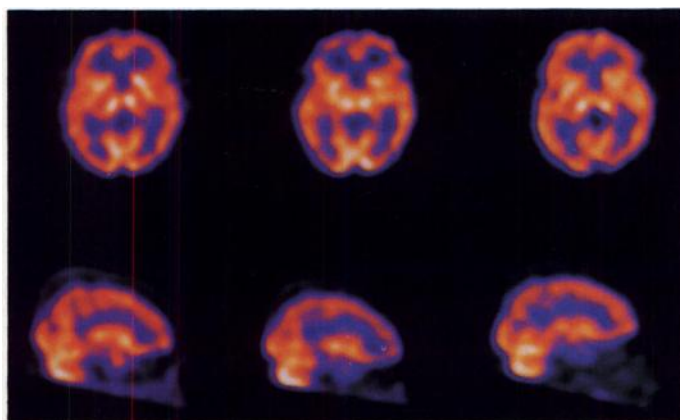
Technetium-99m-HMPAO SPECT images of a 55-yr-old woman with CABG. Axial (top) and sagittal (bottom) images. Left column before surgery, middle column 6 wk after surgery and right column 5 mo after surgery. She had cognitive deterioration and depressive mood at 6 wk after surgery. Frontal hypoperfusion is seen at this time. Five months after surgery, the patient was asymptomatic and frontal perfusion increased.
